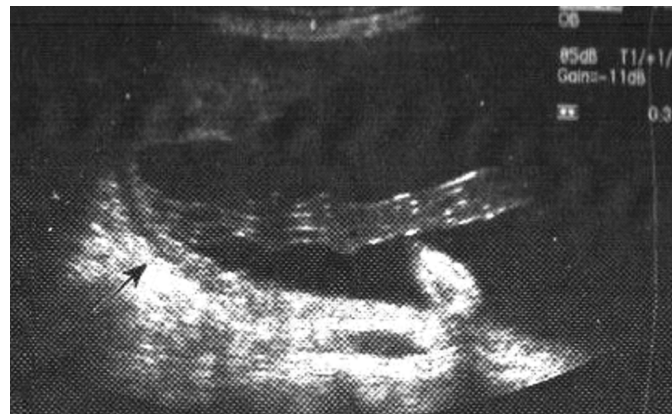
Ultrasound image of velamentous cord insertion
